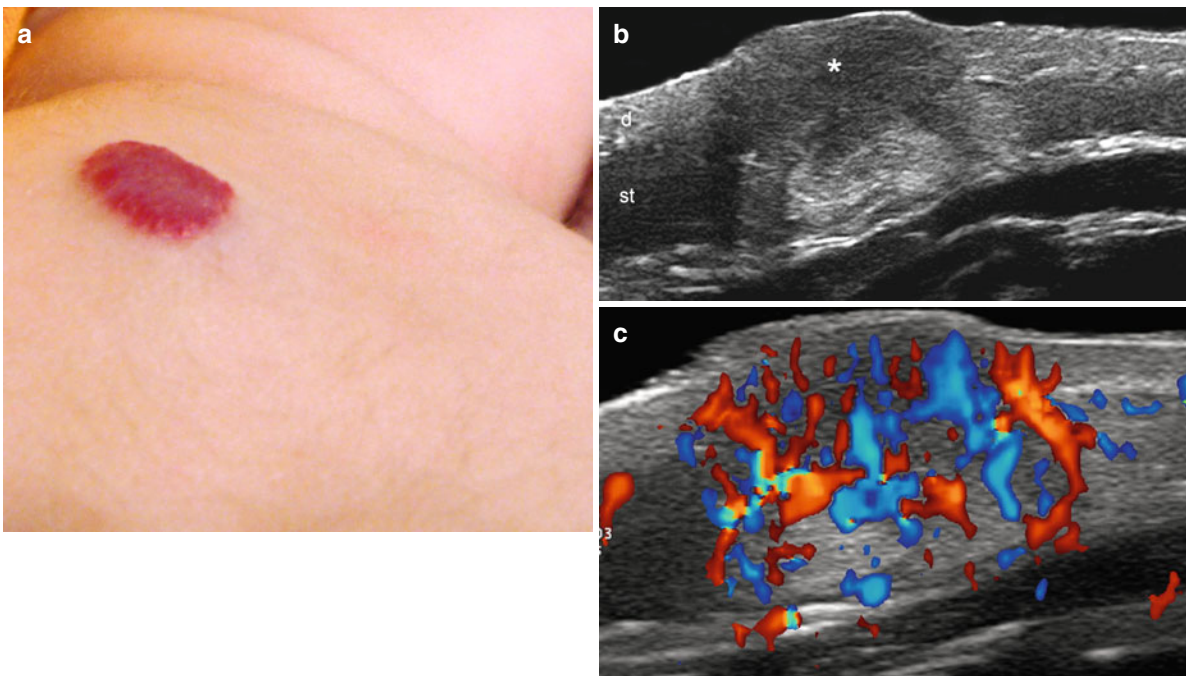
(a–c) Hemangioma (mostly proliferative phase). (a) Clinical lesion shows erythematous bump in the dorsal region. (b) Grey scale ultrasound image (transverse view) demonstrates a mass with prominent hypoechogenicity (*) in the dermis and upper subcutaneous
